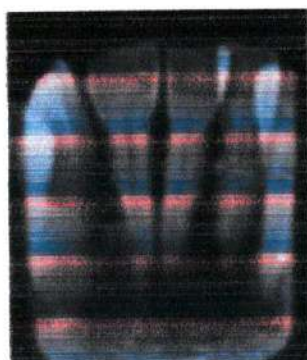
Periapical photos appear radiolucent in 2/3 alveolar bone at 31, 32 and 41
